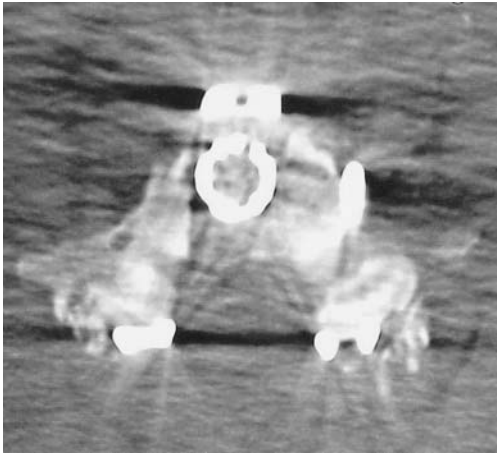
Postoperative CT scan of left C7 pedicle screw which protrudes laterally from vertebral body.
